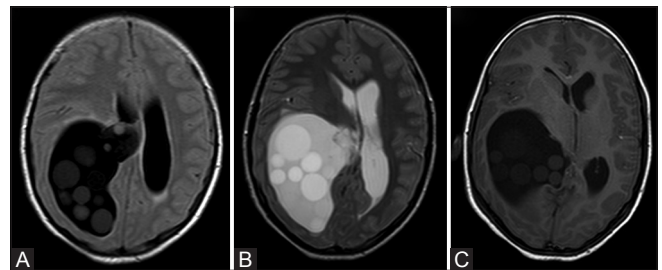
(A-C): (A and B) FLAIR and T2 axial images at the level of body of lateral ventricles. The multiple varying sized lesions in the temporal and occipital horn are well depicted. The lesions appear brighter than CSF on all sequences. And are well seen on the FLAIR images. (C) T1W axial section at slightly lower level at the thalamus revealing similar findings
